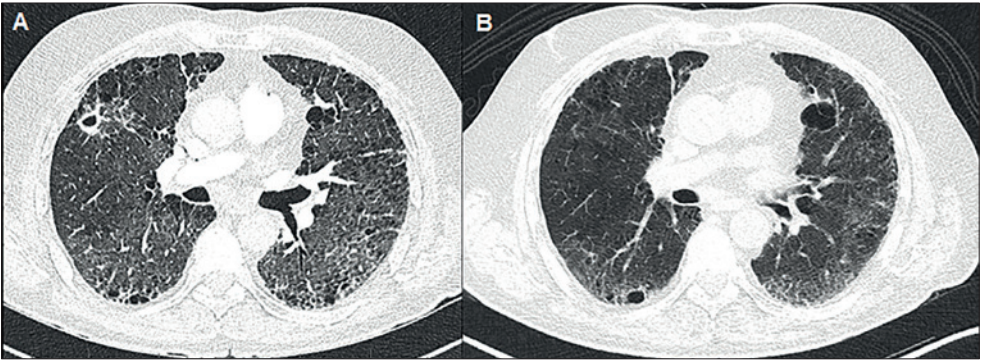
Thorax CT scan in March 2021 (A) and May 2021 (B).
